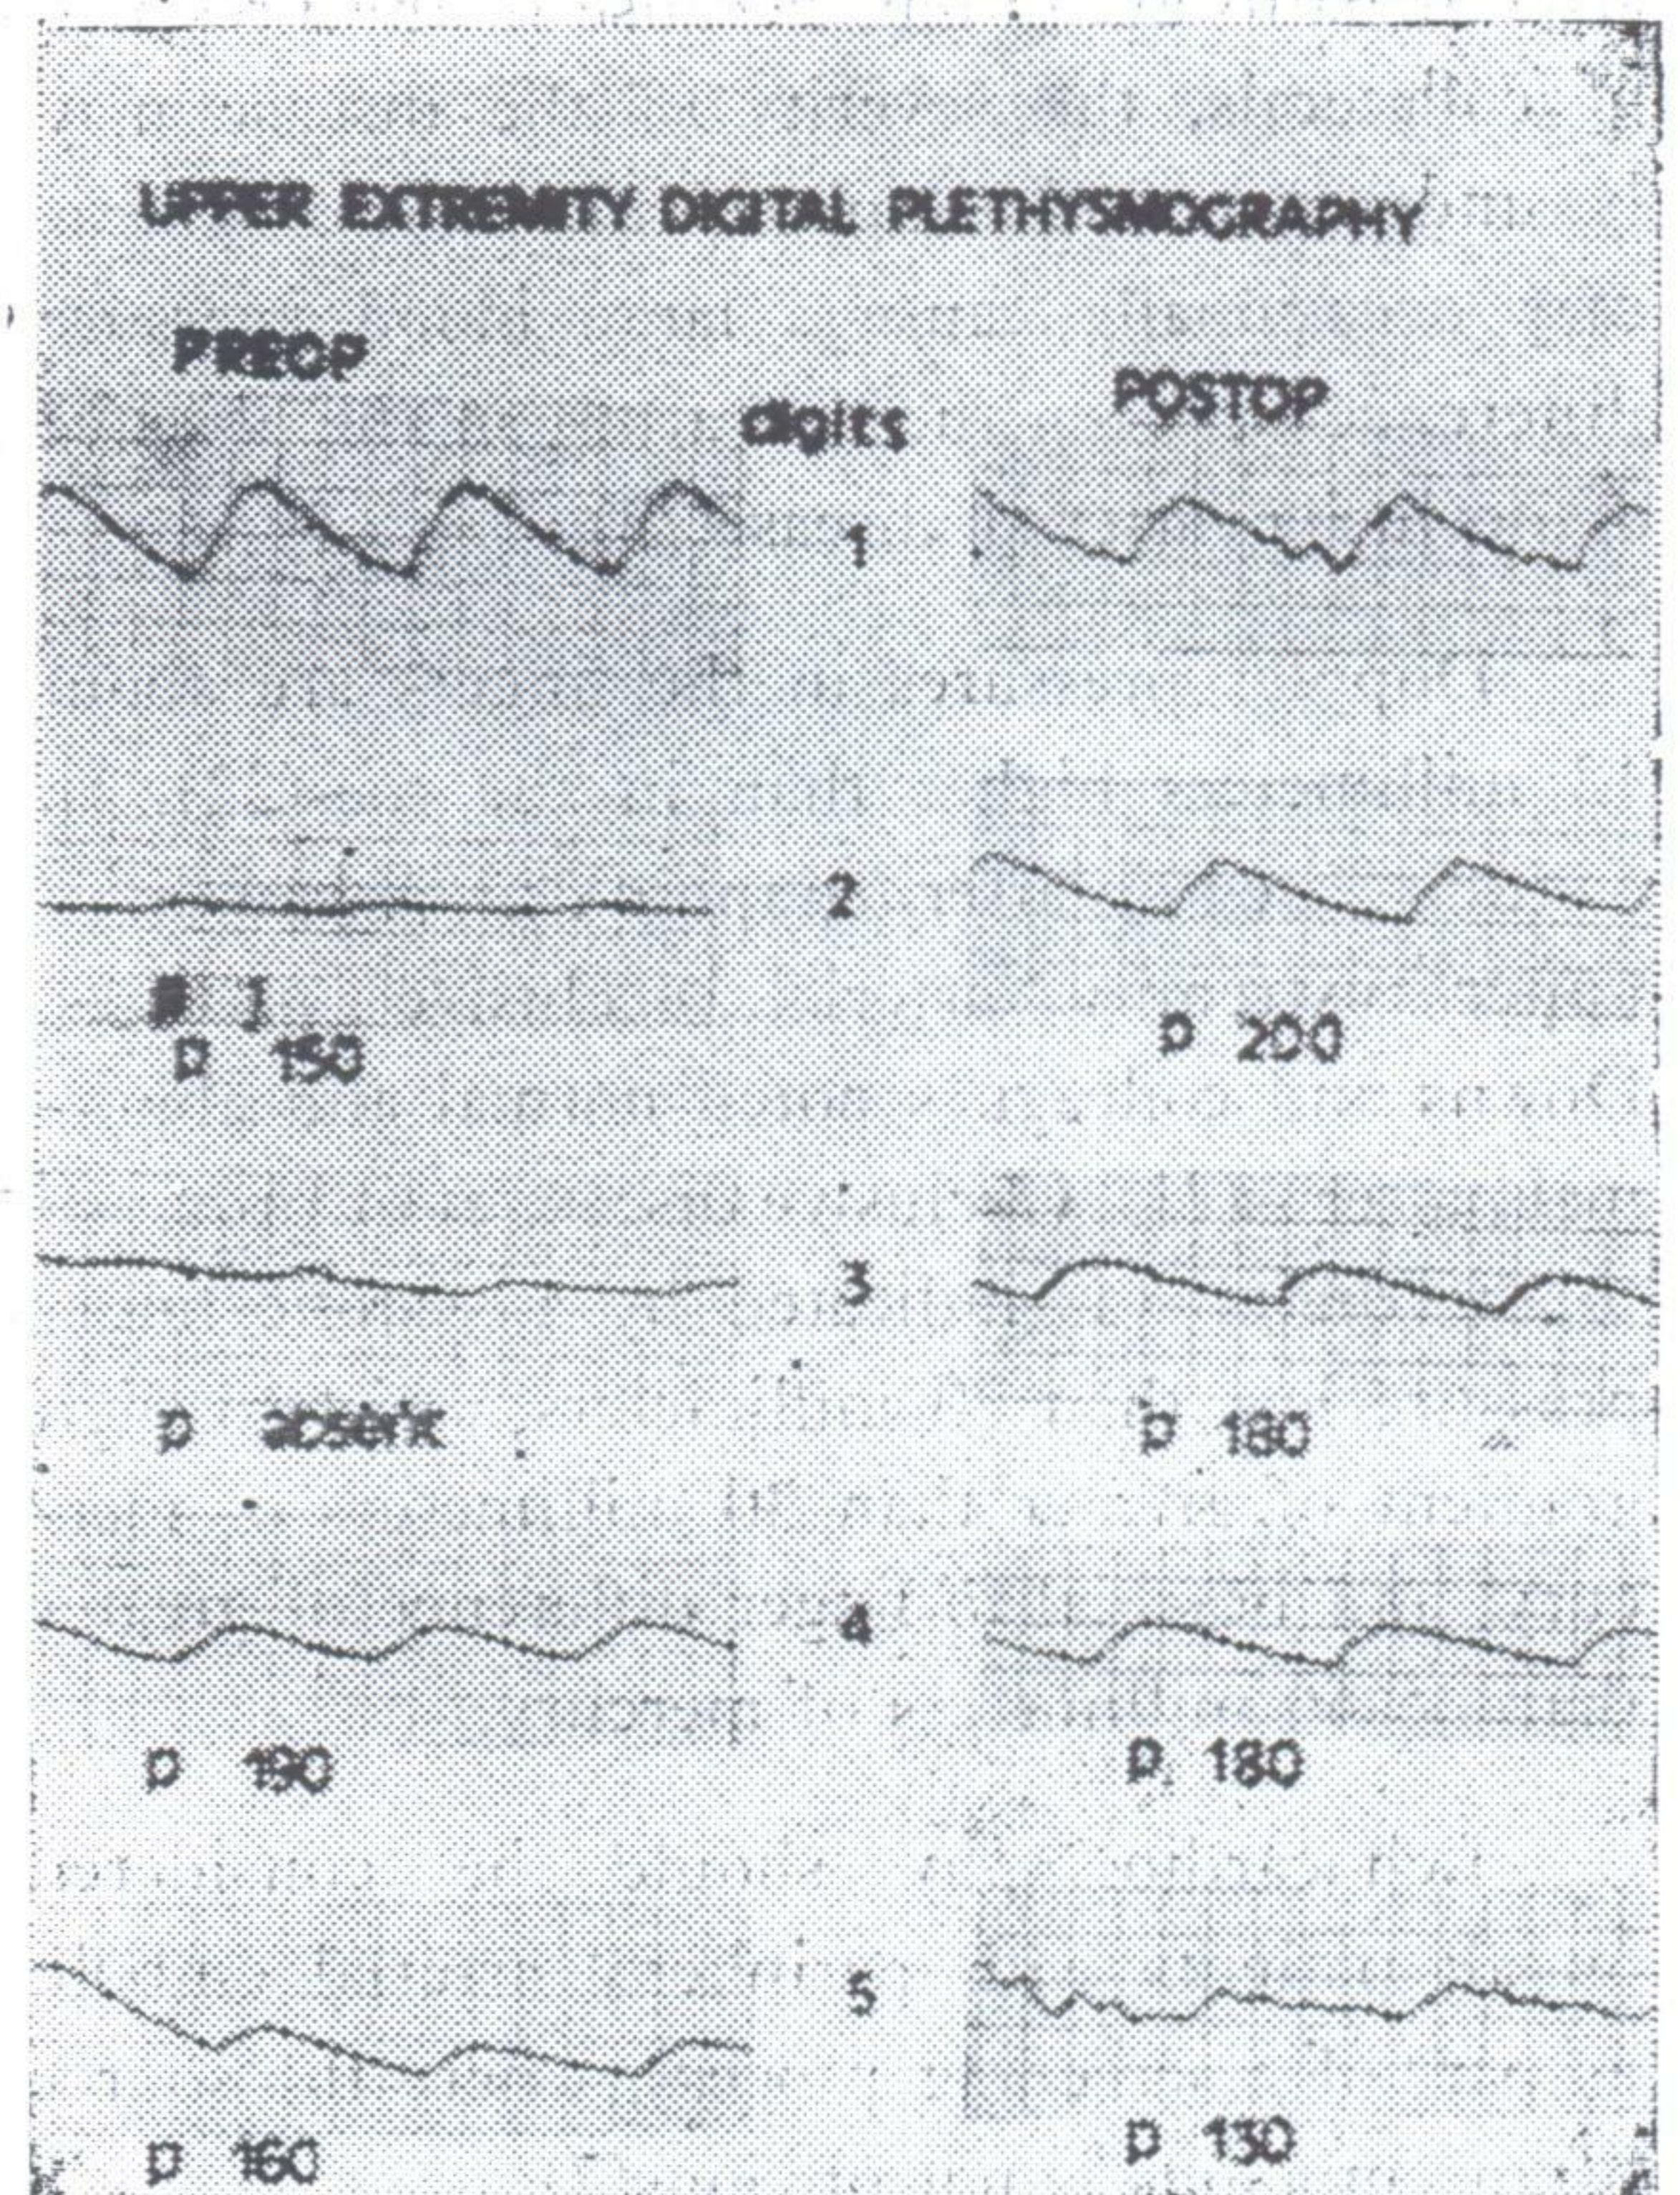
Clinically successful transthoracic cervicodorsal sympathectomy for distal ischemia confirmed by improvement in postoperative pulse volume recordings.
